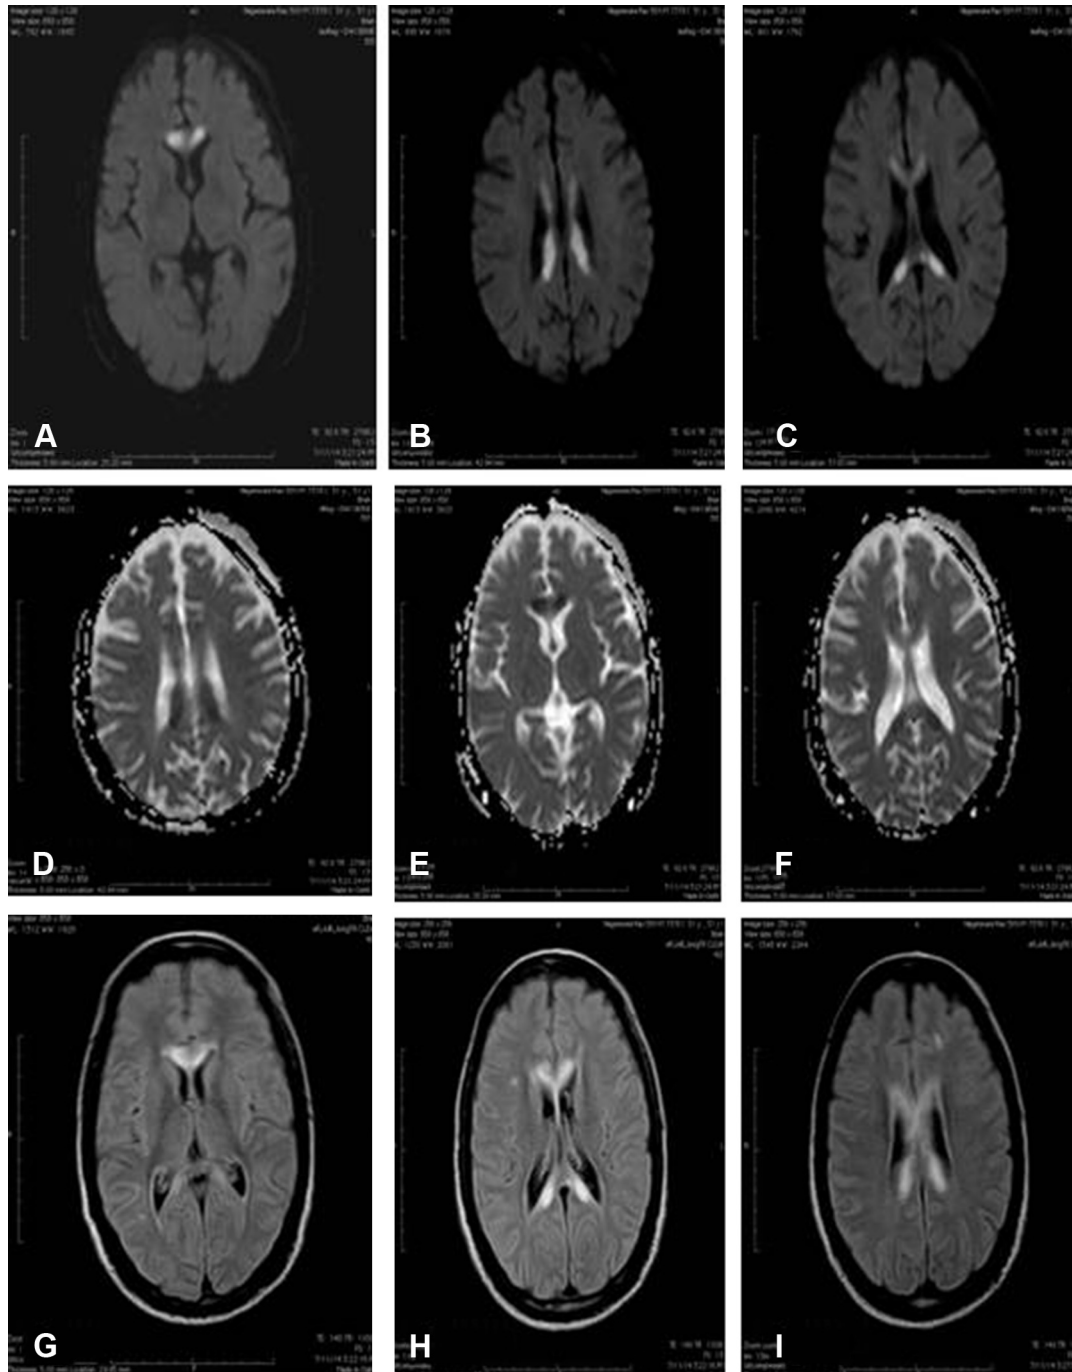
A–C: MRI brain axial diffusion weighted images show restricted diffusion in the genu, body and splenium of corpus callosum. D–F: Corresponding ADC images show low apparent diffusion coefficient values. G–I: Axial FLAIR sequences show hyperintensities in the genu, body and splenium of corpus callosum.
